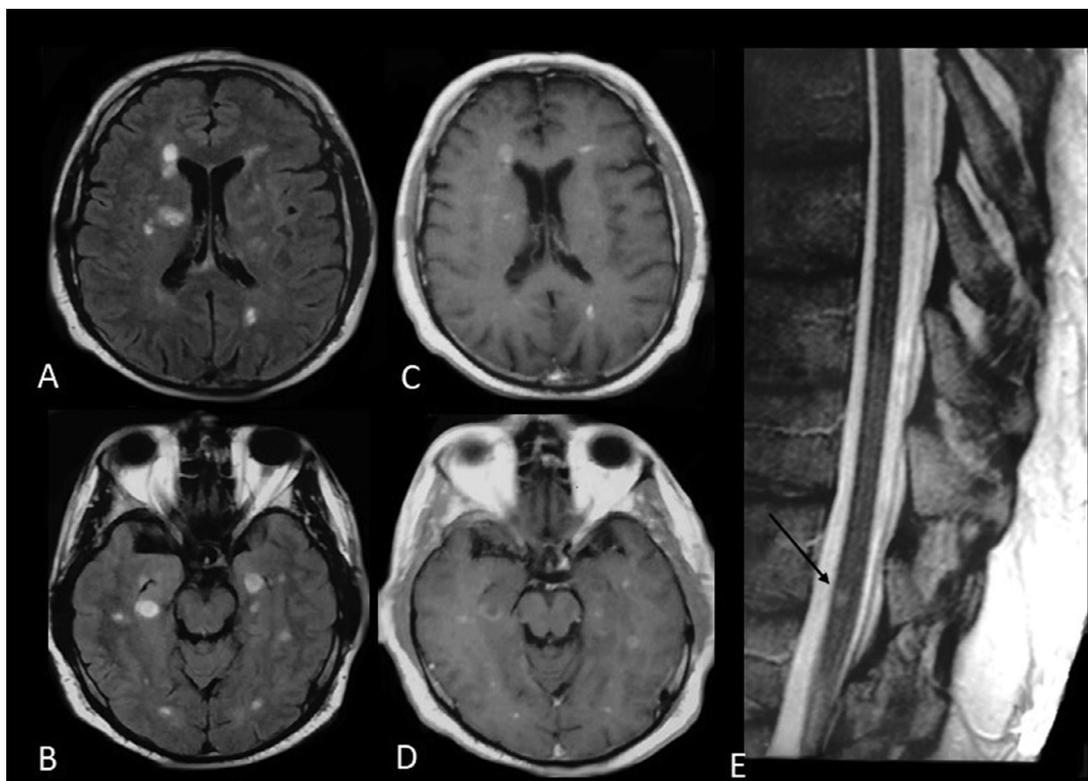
MRI Findings in 2009: MRI scans at the initial presentation in 2009. The FLAIR-weighted sequences of the brain (A, B) show multiple hyperintense lesions in the subcortical white matter, corpus callosum, and semioval center. The T1-weighted sequences with Gadolinium (C, D) show multiple GE lesions. The T2-weighted sequences of the spinal cord (E) show a hyperintense lesion at D11-D12 level.
